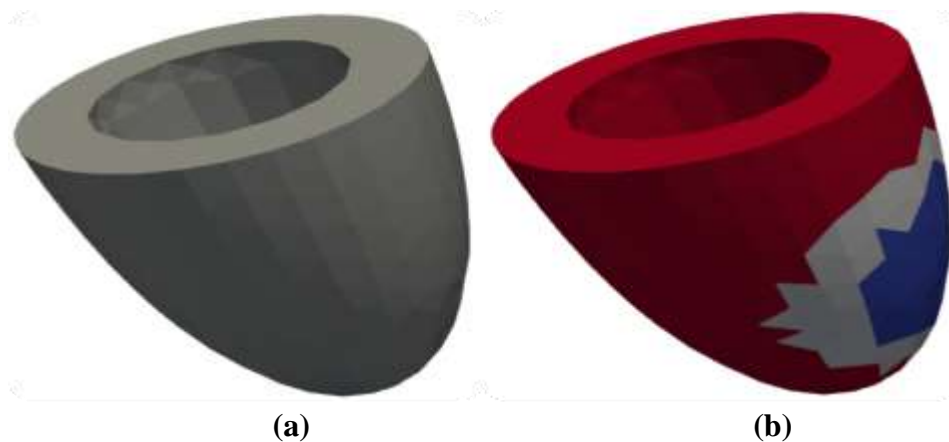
Half prolate ellipsoid geometrical models of LV, constructed based on the acquired MRI images of (a) normal subject and (b) AMI patient.
